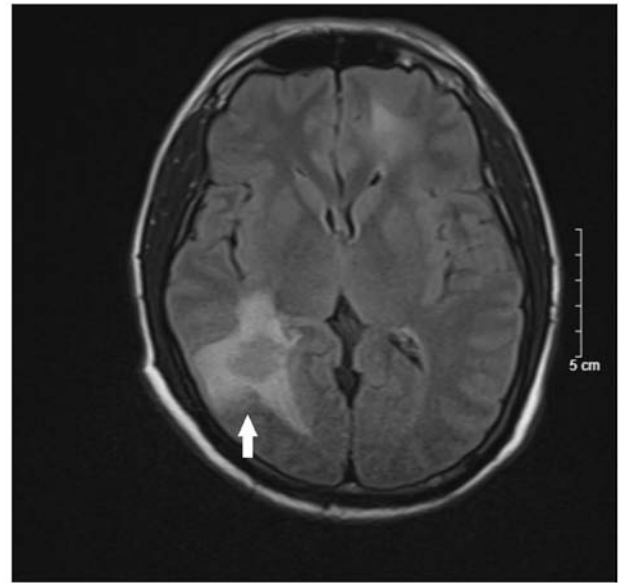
Cranial magnetic resonance image in March 2022 shows the lesion (white arrow) and extensive edema.
